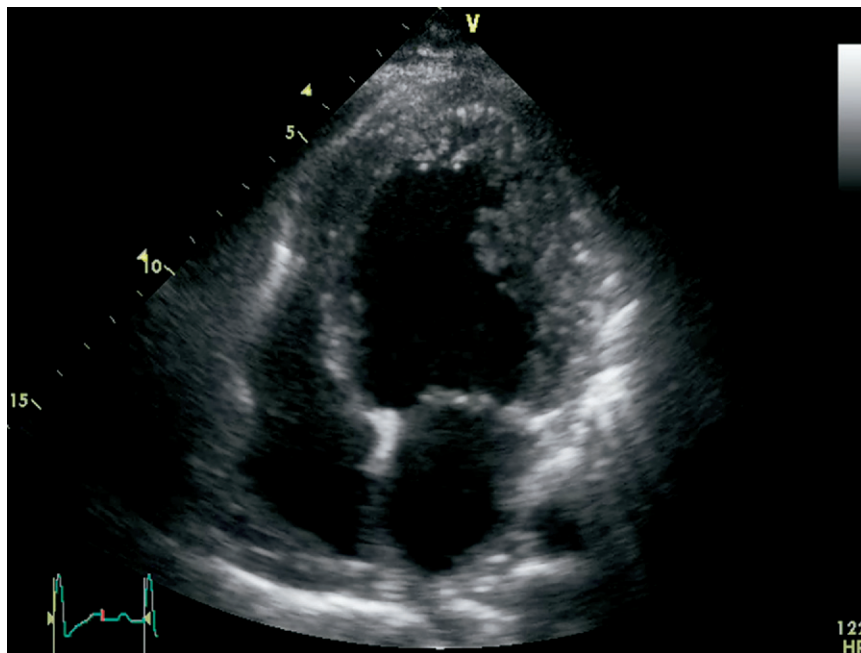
Two-dimensional echocardiogram (apical 4-chamber view) showing prominent trabeculations and recesses in noncompacted left ventricle.
